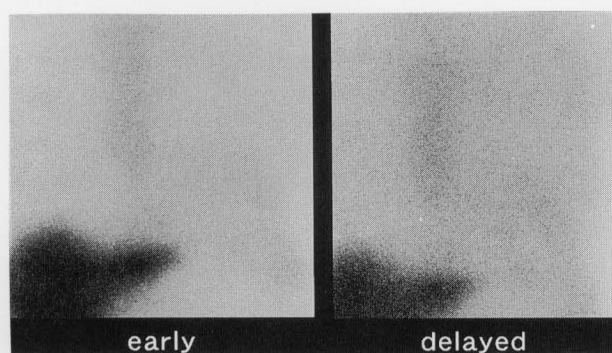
^{99m}Tc -tetrofosmin myocardial planar and SPECT images in 1995. Planar and SPECT images show myocardial accumulation.
